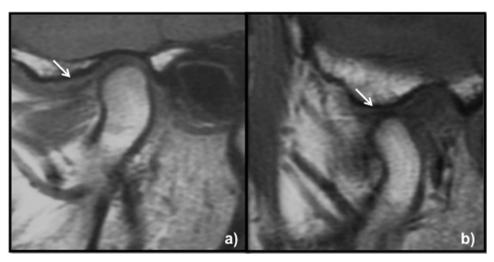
T1-weighted sagittal view: (a) mouth closed – note that the articular disc (hypointense area, arrow) is in a position prior to 11:30 h in relation to the mandibular condyle; (b) mouth open – the articular disc returns to its original position, with the intermediate zone located between the mandibular condyle and the articular tubercle, characterizing disc displacement with reduction (DDWR).
